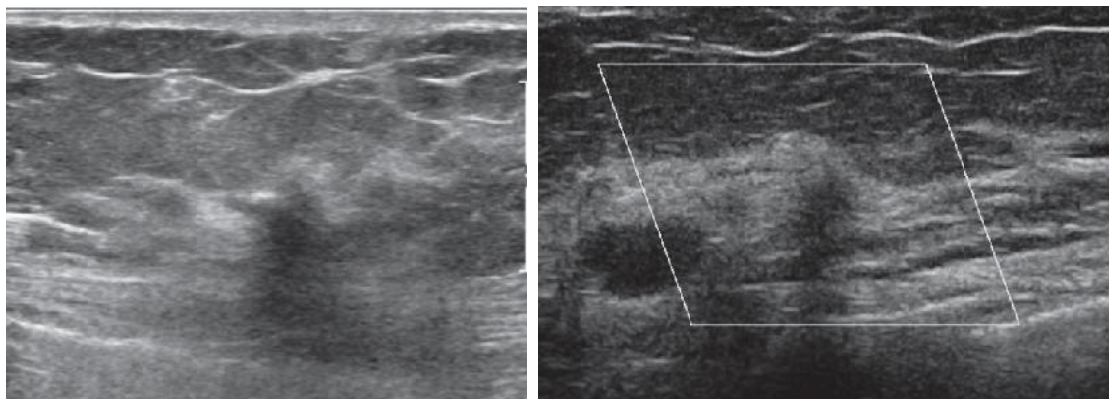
Ultrasound showing suspected lesion and enlarged left axillary lymph nodes.
